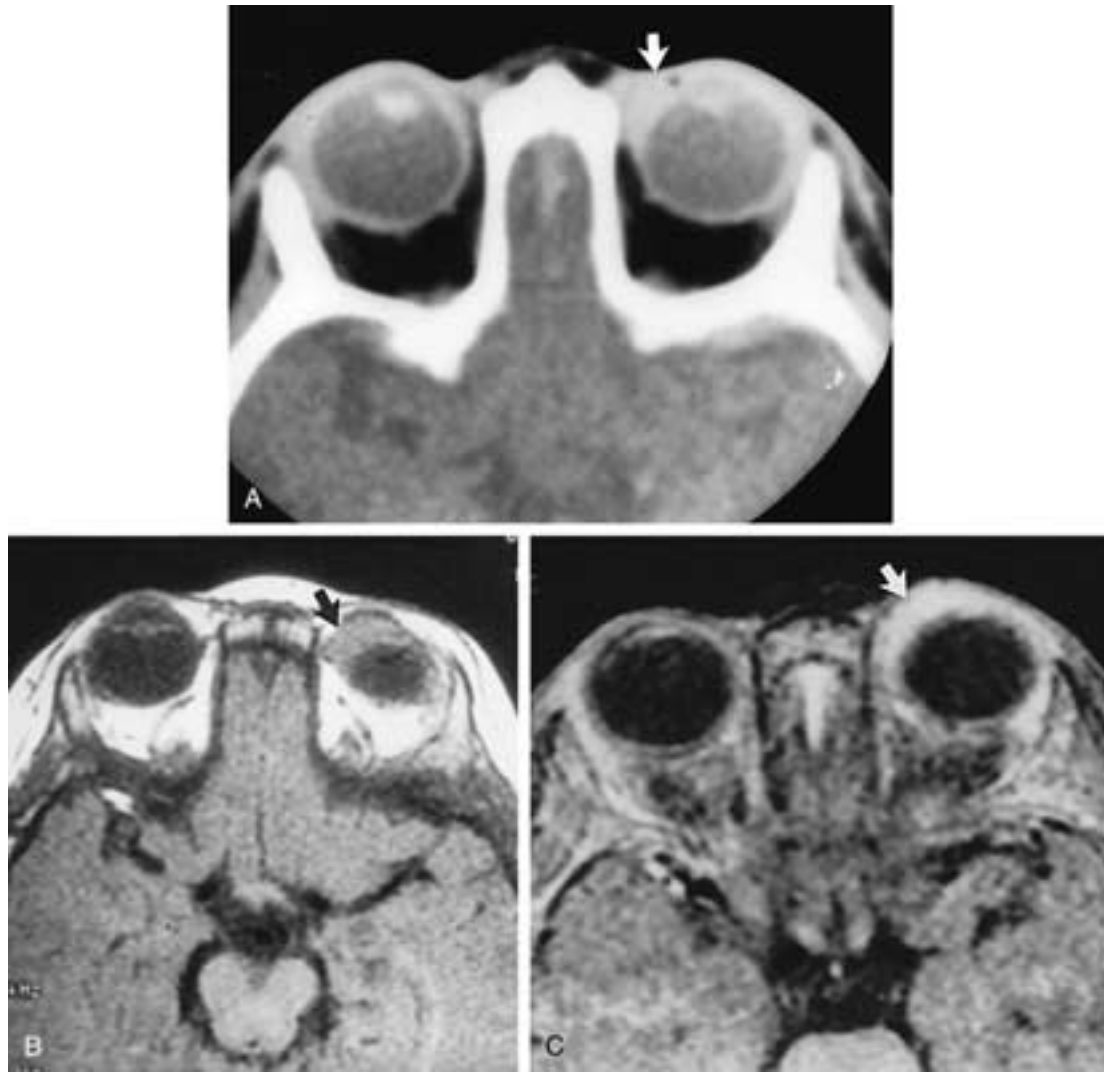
JXG of the orbit. A, Enhanced axial CT scan shows an enhancing infiltrative process involving the medial orbital region (*arrow*). B, Axial T1-weighted MR image shows the lesion (*arrow*) to be isointense to brain. C, Gadolinium-enhanced, fat-suppressed axial MR image shows marked enhancement of the orbital lesion (*arrows*). The lesion was adherent to the sclera. (From Hidayat AA et al. Langerhans' cell histiocytosis and juvenile granuloma of the orbit. *Radiol Clin North Am* 1998;36:1229–1240.)
